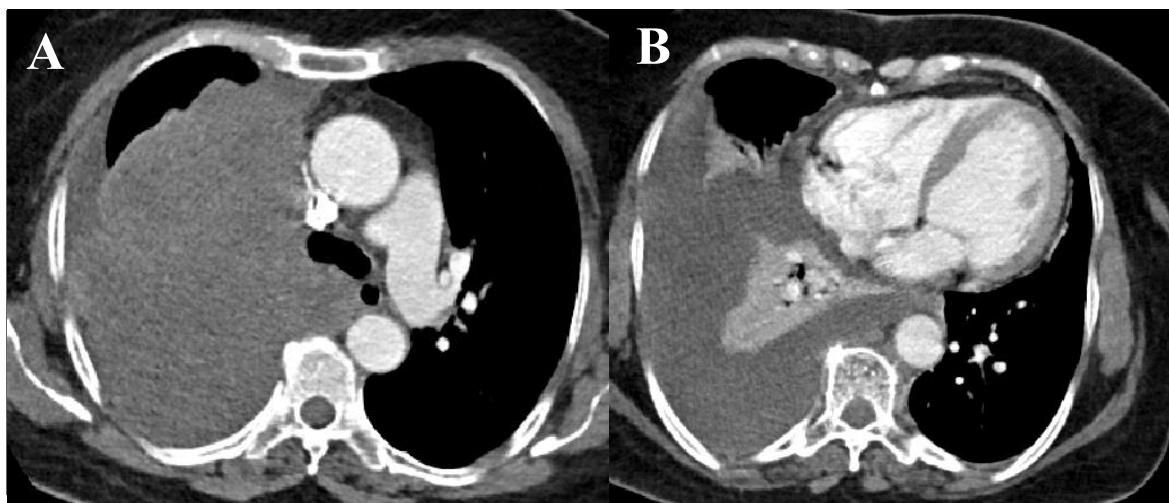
Axial mediastinal window images from a contrast-enhanced chest CT demonstrating a large right upper lobe mass (A). Adjacent right-sided pleural effusion with nodular pleural enhancement is visible, along with collapse of the right lower lobe (B). Mild right-sided pericardial effusion is also present.
